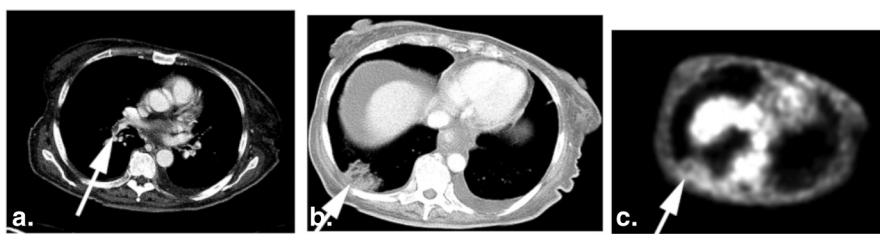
Example of peripheral pulmonary infarction with associated complete rim of FDG avidity. A 66-year-old woman with a history of gastric cancer. Contrast-enhanced computed tomography demonstrates a pulmonary embolism involving the interlobar pulmonary artery (a) and a right lower lobe pulmonary infarction (b). The associated PET demonstrates a rim of FDG avidity at the borders of the infarction (c). FDG, fluorodeoxyglucose; PET, positron emission tomography.
